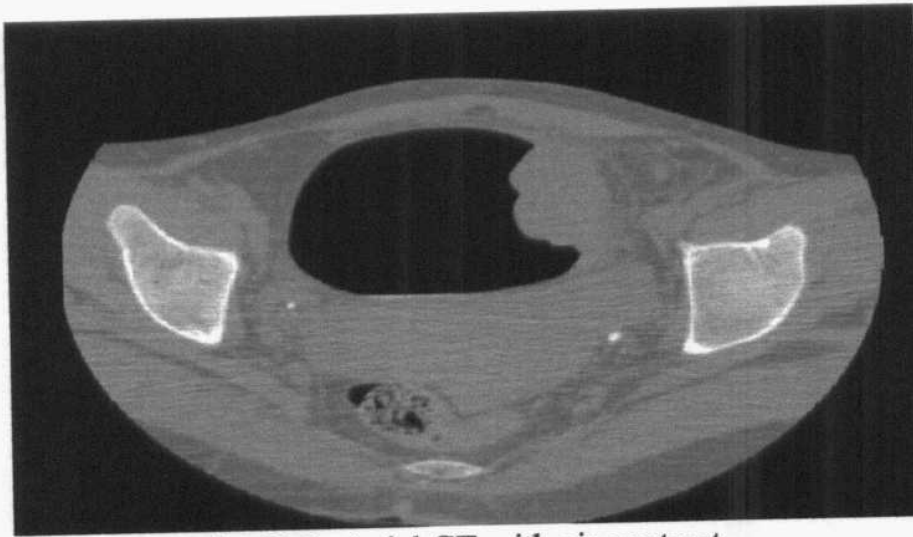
Axial CT with air contrast
